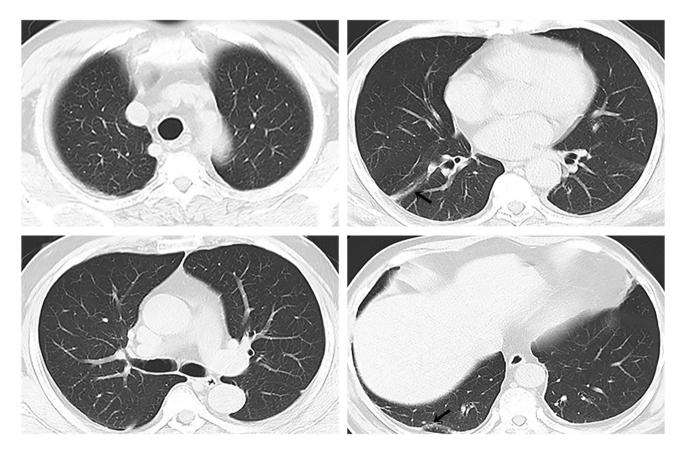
Chest CT on day 20 of hospitalization showing almost normal pulmonary imaging features (arrows).
